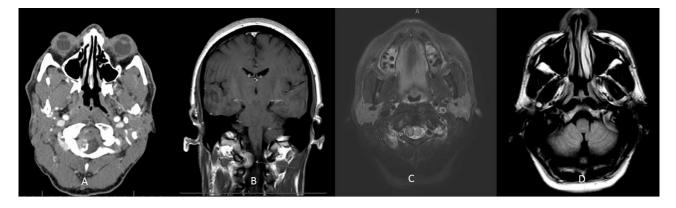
Neck computed tomography angiogram shows a calcified intrathecal mass at the level of C1-C2 with mass effect upon the adjacent cord (A). Magnetic resonance imaging shows the mass to be intrathecal, extramedullary, dural based, and enhancing suggestive for meningioma on coronal post contrast T1 sequence (B) and axial T2 sequence (C). No evidence of edema or infarction in right cerebellum on axial Fluid attenuation inversion recovery (FLAIR) sequence (D).
